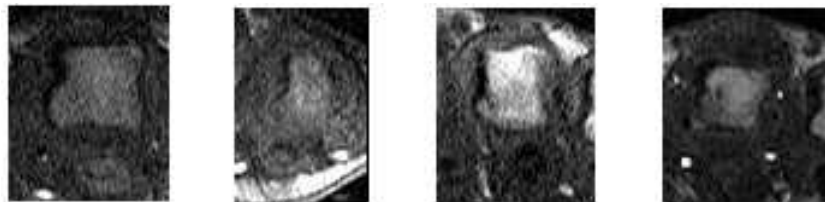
Regions corresponding to the bone interiors (brighter colours) and surrounding tissues from different DCE-MRI studies. Contrast and intensity of the bone marrow and surrounding tissues varies significantly from study to study.
